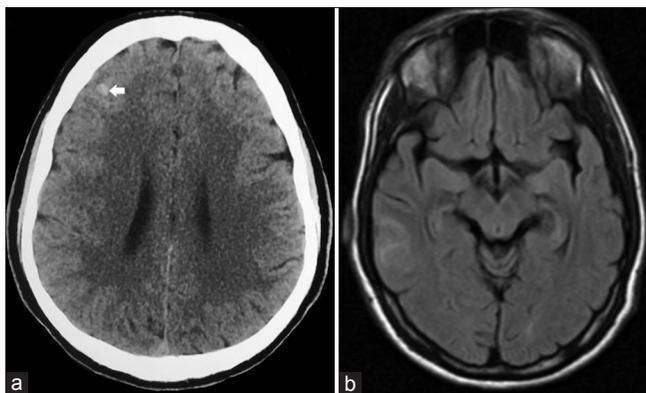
(a) Computed tomography showing intracerebral hemorrhage involving cortex of the right frontal lobe (arrow), (b) magnetic resonance imaging of the brain showing T2-fluid-attenuated inversion recovery hyperintensity in the right inferior and middle temporal gyrus due to transverse sinus thrombosis
